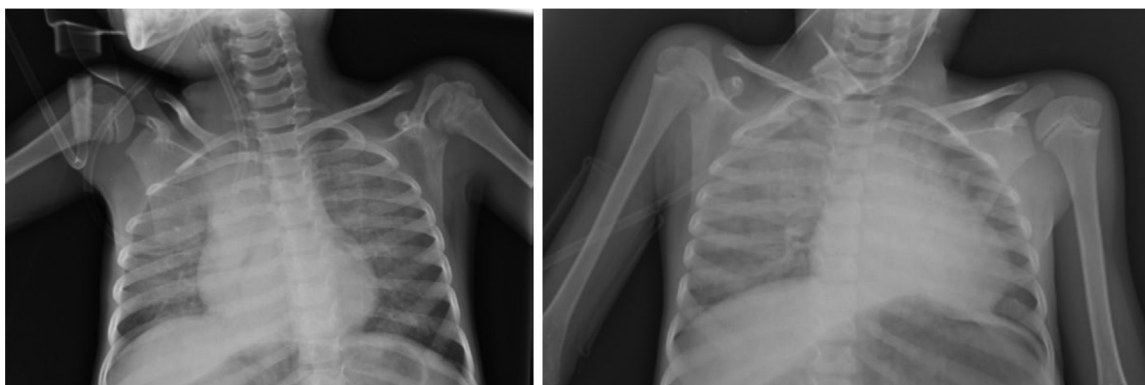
(a) Posterior-anterior chest radiography at the postoperative 20th minute. (b) Posterior-anterior chest radiography at the postoperative 2nd hour (after furosemide treatment was stopped).
